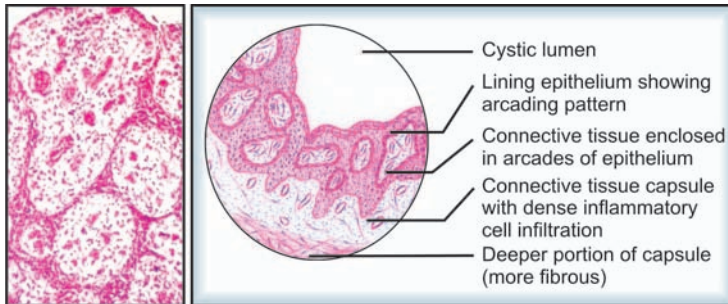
Radicular cyst (periapical cyst, apical periodontal cyst, root end cyst)
